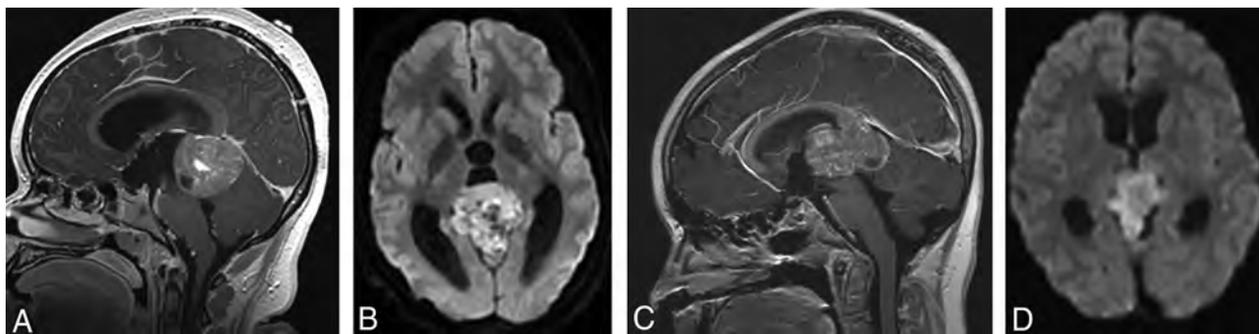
(A and B), A 15-year-old girl with a molecular diagnosis of pineoblastoma. Sagittal T1-weighted postcontrast (A) and axial diffusion-weighted (B) MR images demonstrate a mass centered in the pineal region with diffuse heterogeneous enhancement, small cystic foci, and diffusion restriction. (C and D), A 9-year-old girl with a molecular diagnosis of ATRT_MYC. Sagittal T1-weighted postcontrast (C) and axial diffusion-weighted (D) images demonstrate a similar mass centered in the pineal region with diffuse heterogeneous enhancement, small cystic foci, and diffusion restriction. Note the similarities in imaging appearance between the 2 examples.
